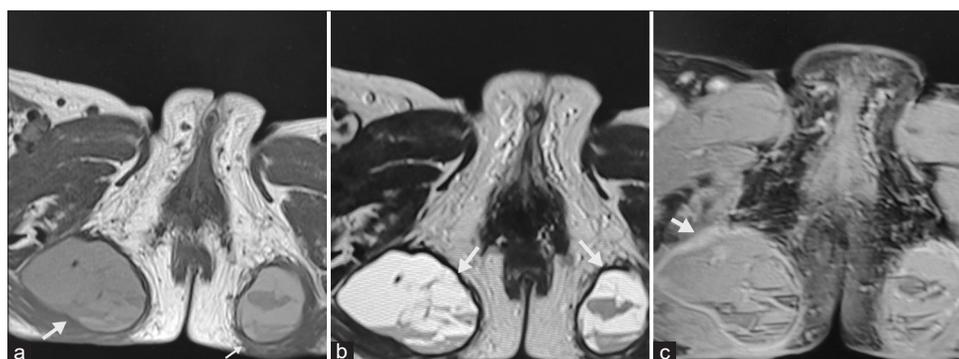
Magnetic resonance imaging pelvis. (a) T1-weighted axial image shows bilateral hyperintense lesions in ischiogluteal plane. (b) T2-weighted axial image shows multiple internal fluid-fluid levels within the lesions (arrows). (c) T1-weighted, post-contrast fat-suppressed image shows that the walls of the lesions enhance in the post-contrast study.
